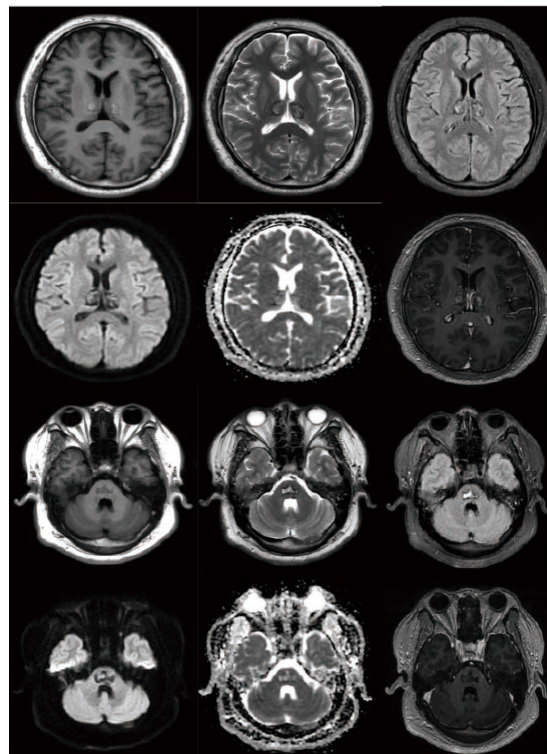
MRI findings in the thalamus and brainstem after two months of treatment.
